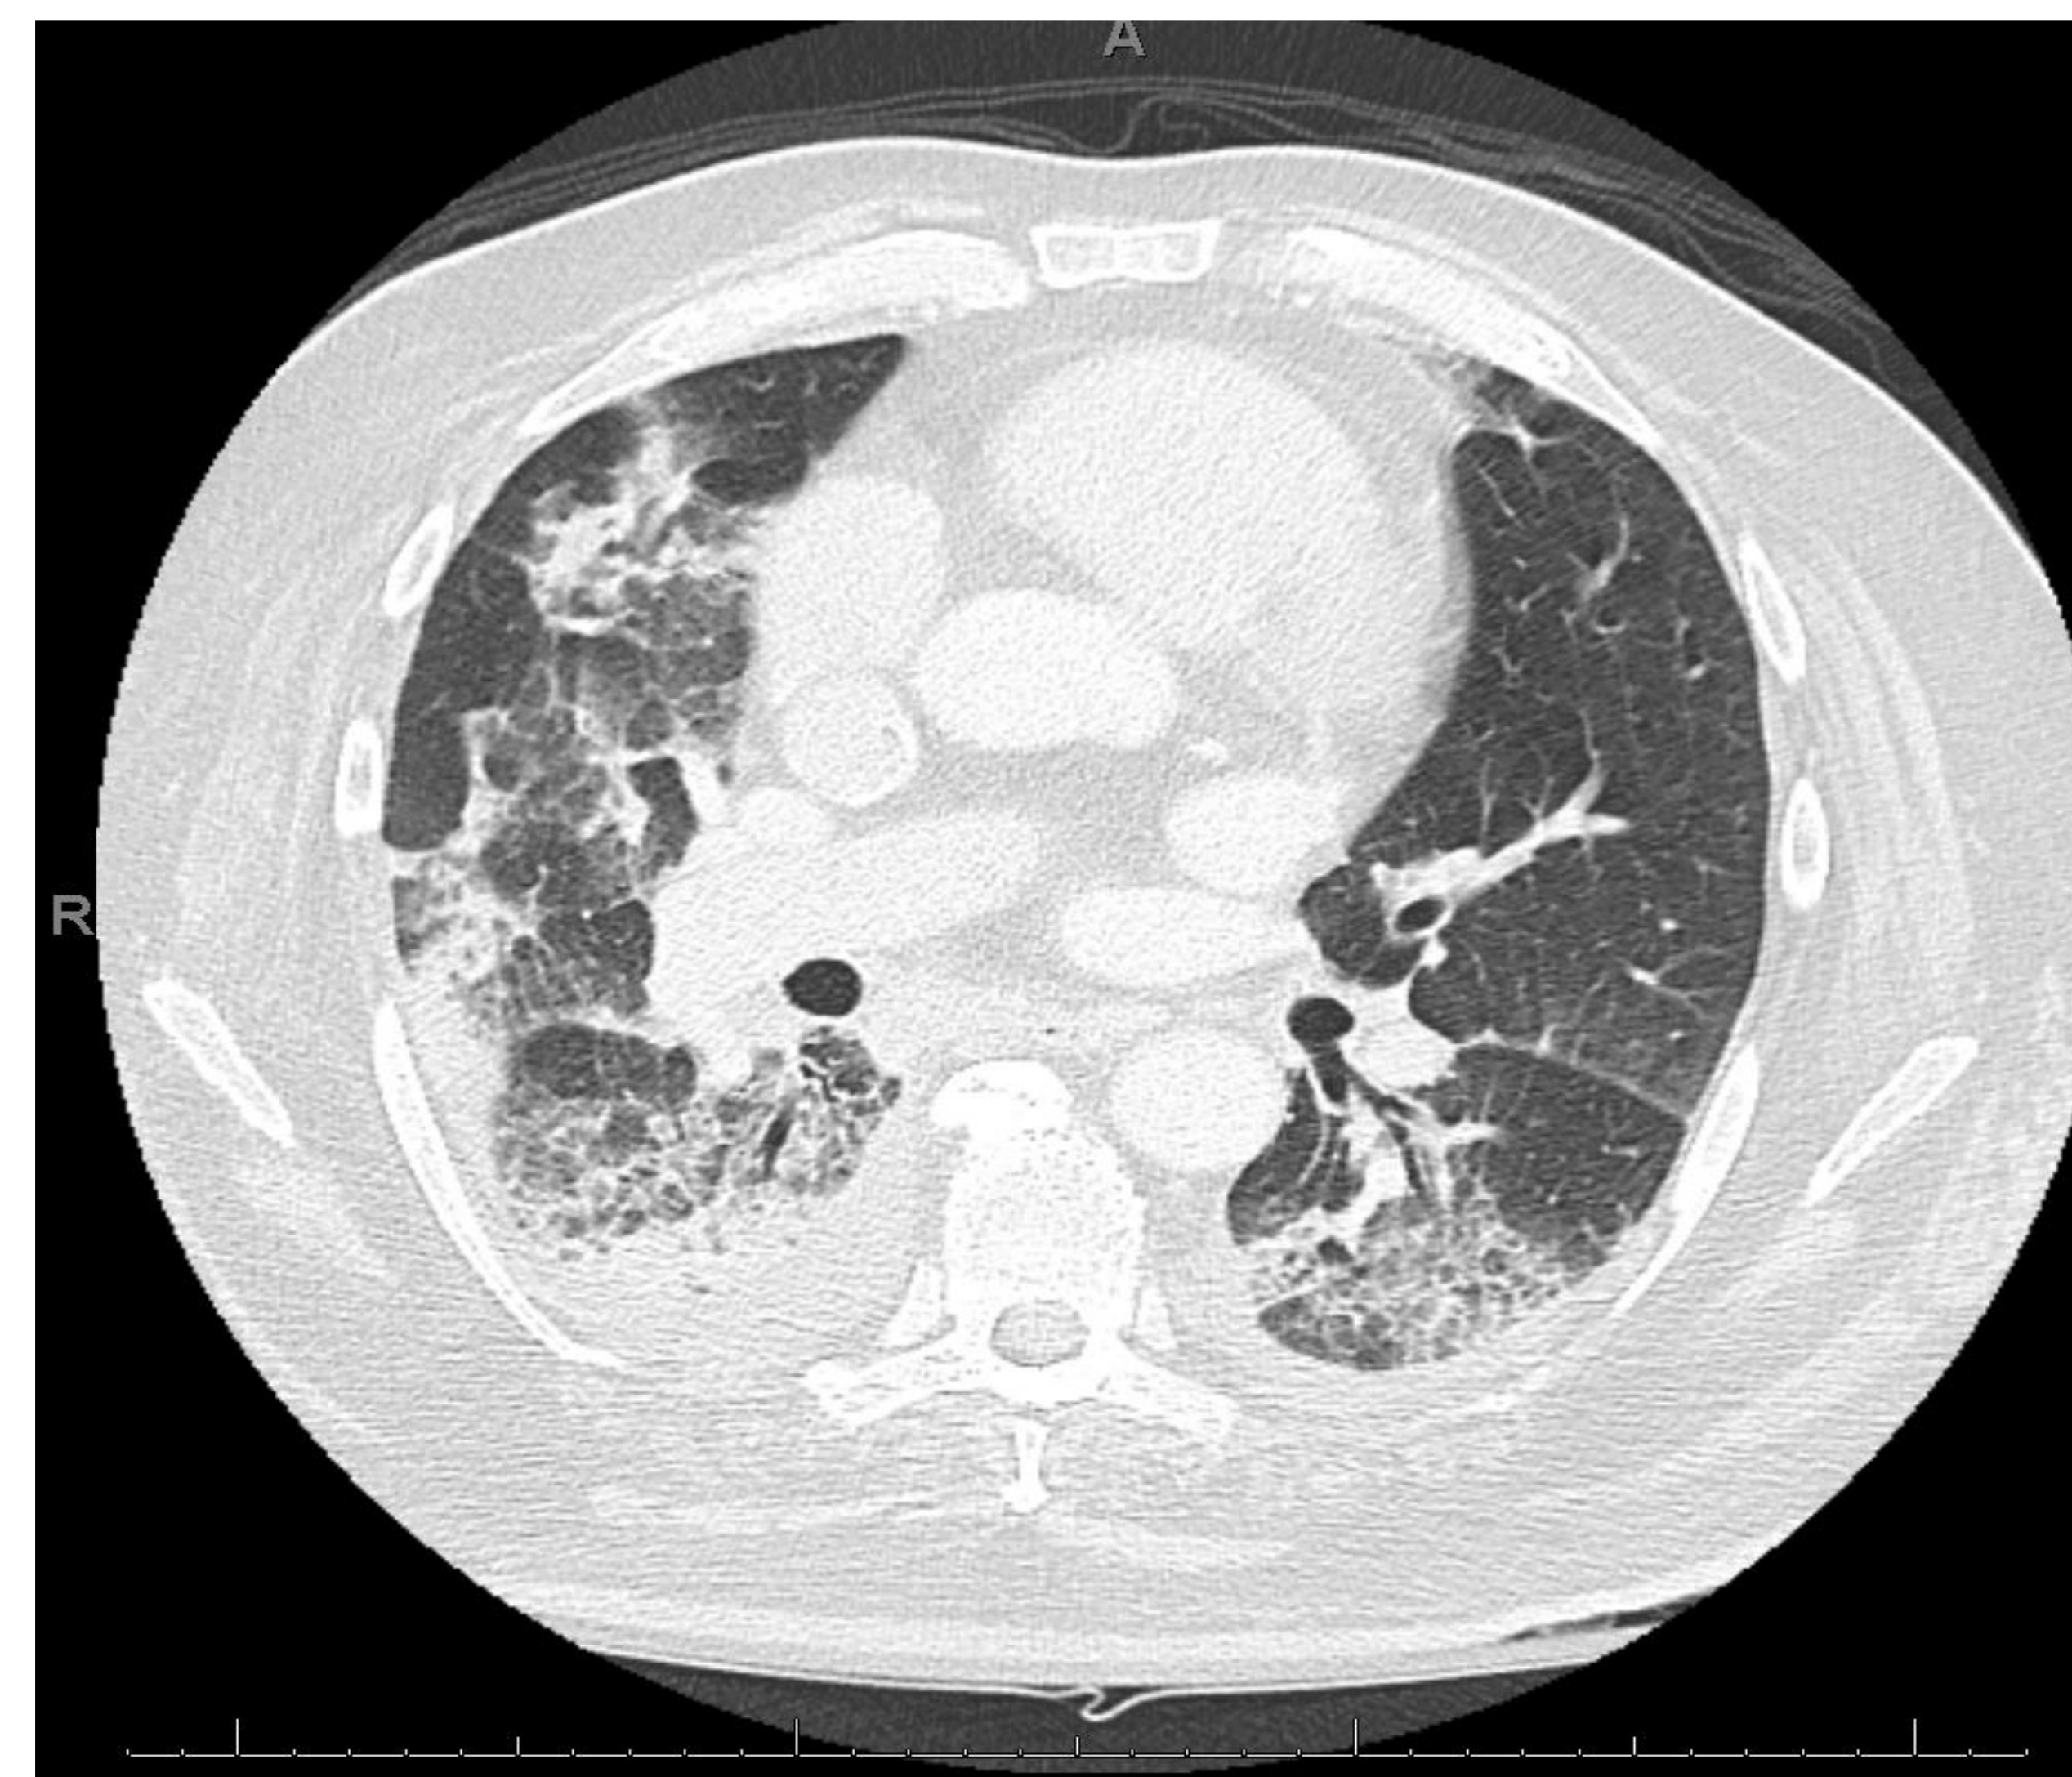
CT scan of the chest showing patchy opacities of both lungs involving all lobes bilaterally with some consolidation changes and mild bilateral pleural effusions
